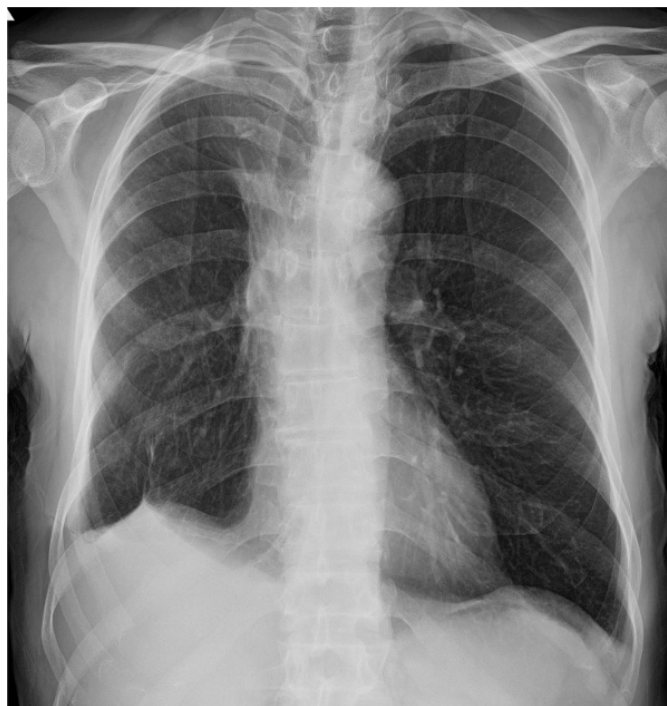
Postoperative 15 month chest radiography.
